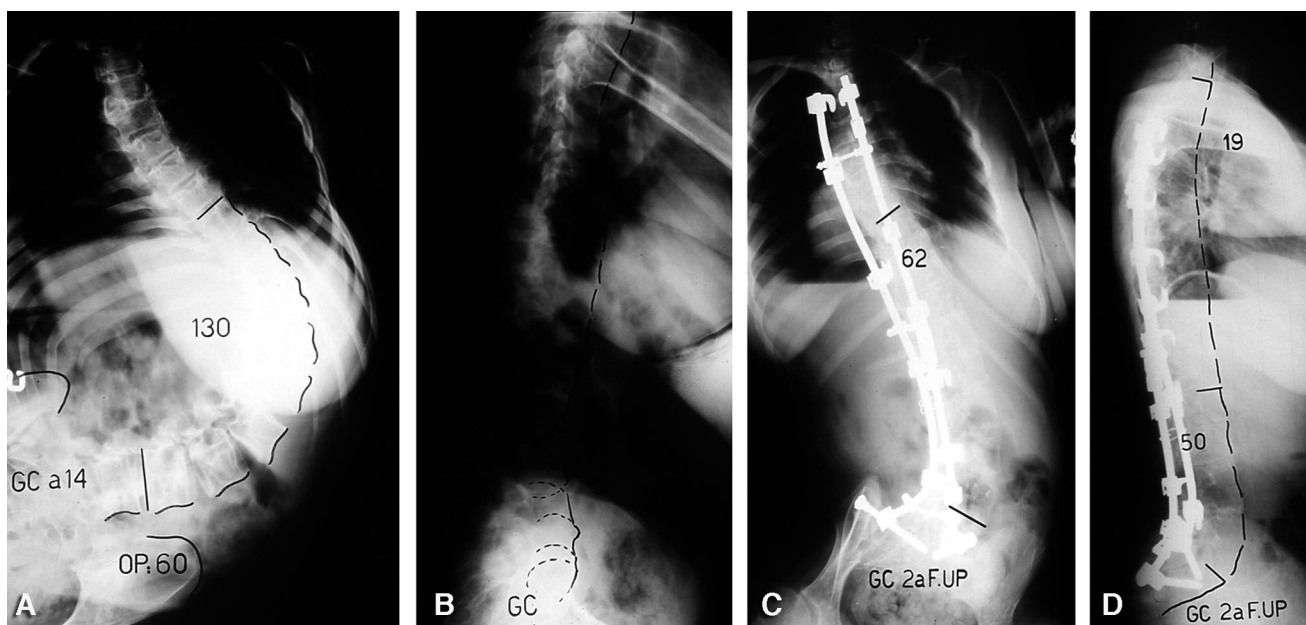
A and B, Posteroanterior and lateral preoperative radiographs of a 14-year-old female patient with spastic quadriplegia treated in 1995. C and D, Posteroanterior and lateral radiographs 2 years following anteroposterior spino-pelvic fusion with tibial autograft.
